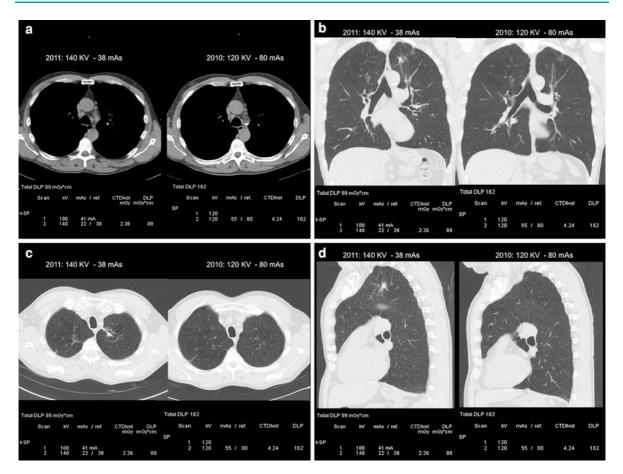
Consecutive chest CT examinations in the same patient with stable body weight of 65 kg obtained in 2010 and in 2011. A pulmonary lesion has appeared in 2011 in the left upper lobe. The 2010 acquisition was obtained with 120 kV and 80 mAs, whereas the second CT was obtained at 140 kV
